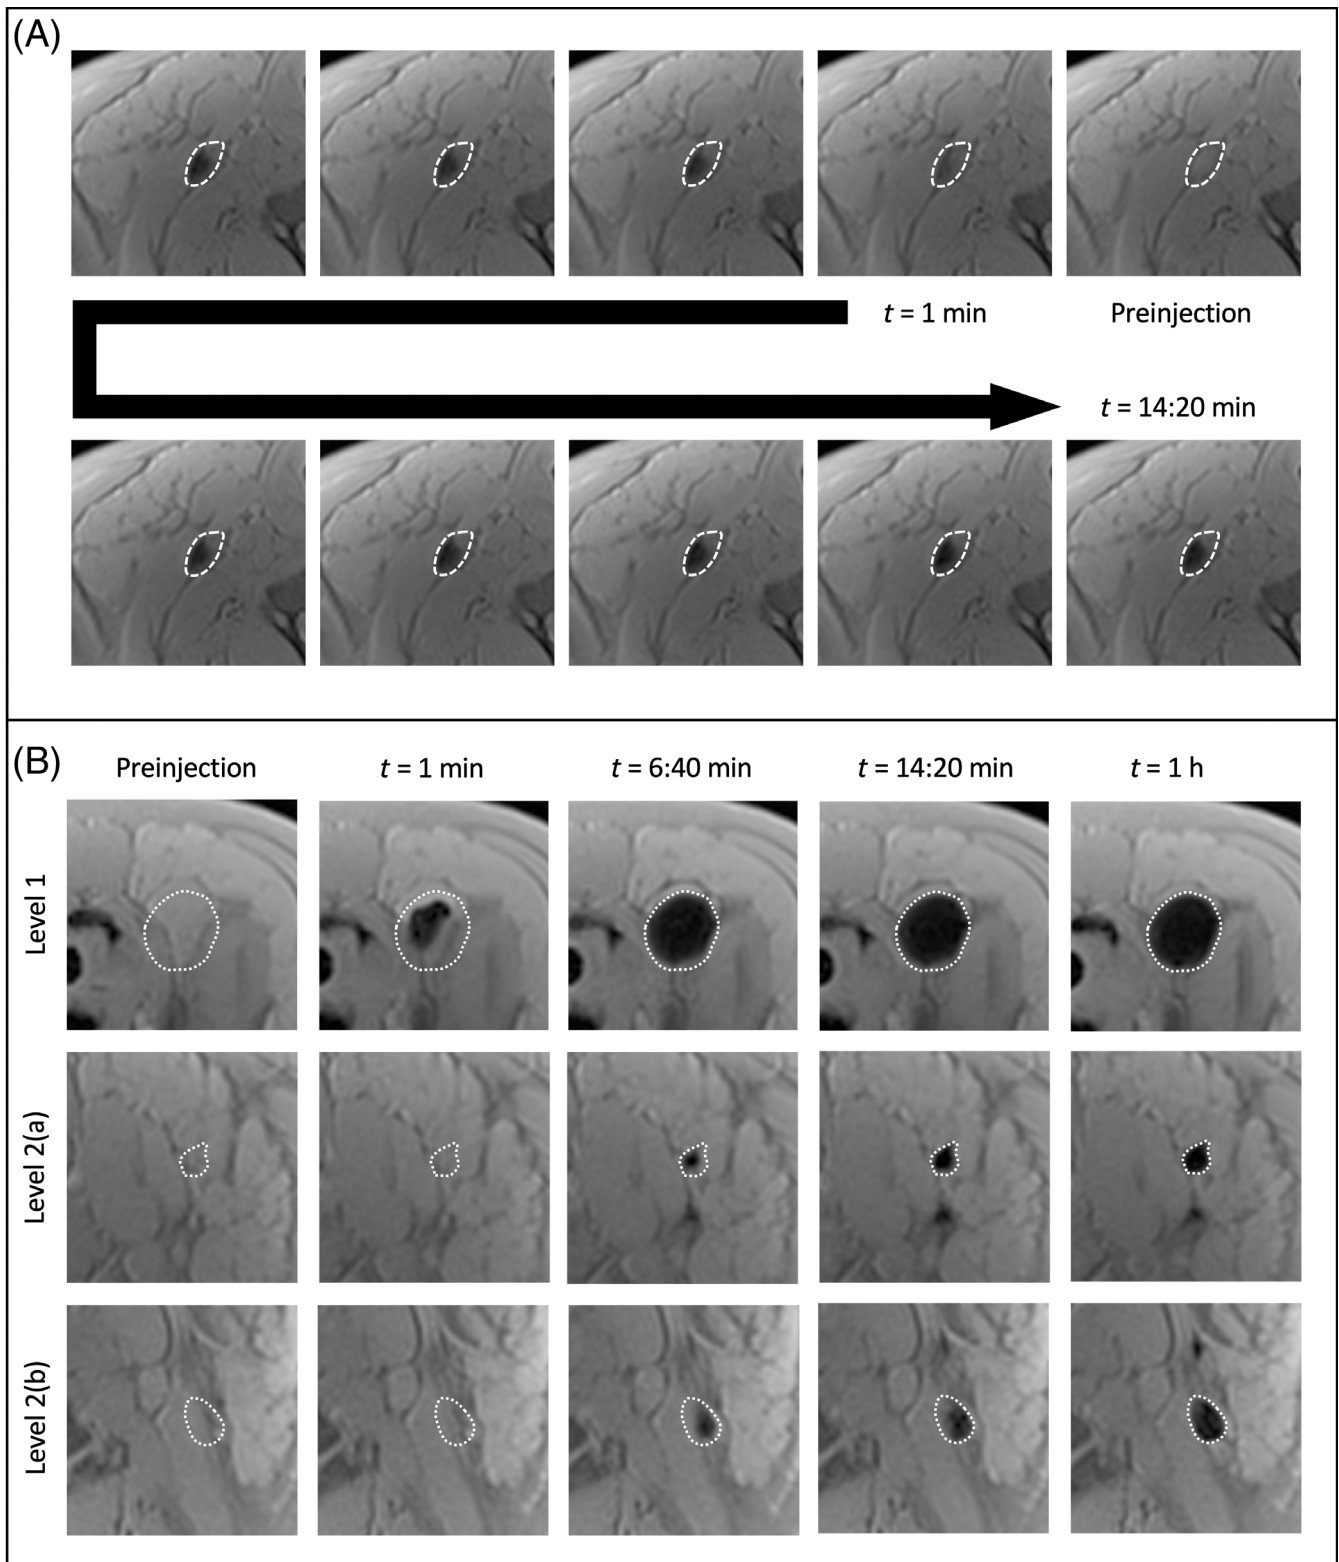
Demonstration of the pseudo-dynamic preoperative MRI sequence. (A): Progressive uptake of FerroTrace into the sentinel node after injection, as viewed on pseudo-dynamic scans acquired every 100 s. (B) Using MRI to differentiate levels in the neck and identify the SLN. Over the duration of the pseudo-dynamic sequence (8 scans over 13 min), there is a clear pattern of drainage from the SLN (seen 1-min postinjection) down to lower echelon nodes (both appearing approximately 5 min after the SLN). SLN, sentinel lymph node
